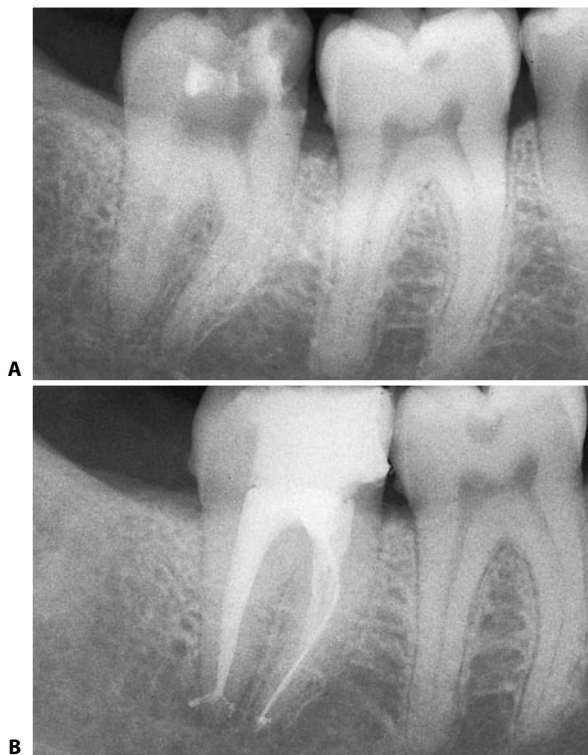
A lower right second molar with a slight curve in the coronal third of the mesial root. A. Preoperative radiograph. B. Postoperative radiograph.
